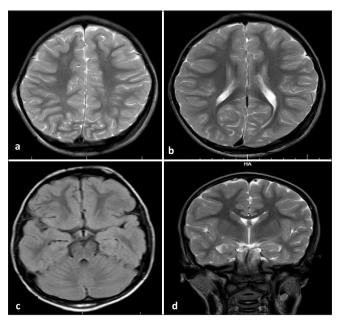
(a-d) Magnetic resonance imaging of the brain not showing any abnormalities.
